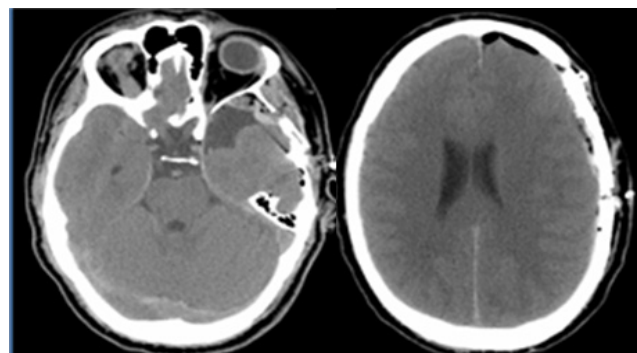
Post-operative brain CT scan with subdural hygroma resolution and reduction of arachnoid cyst volume
